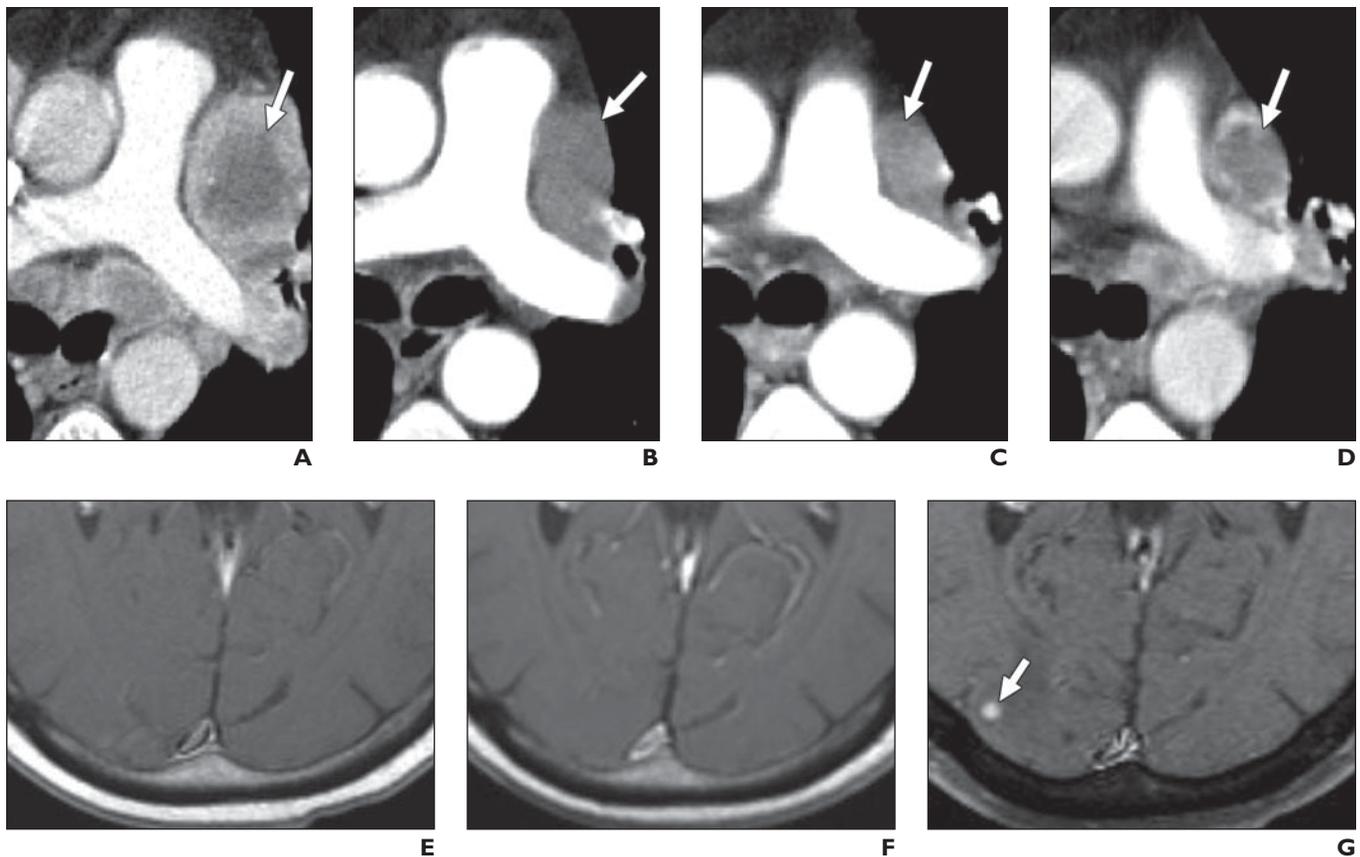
49-year-old man with metastatic renal cell carcinoma (RCC). Contrast-enhanced CT (CECT) at various stages of sunitinib therapy depicts mediastinal/hilar RCC metastases and contrast-enhanced T1-weighted MR images of head depict normal brain initially and brain metastasis later.
